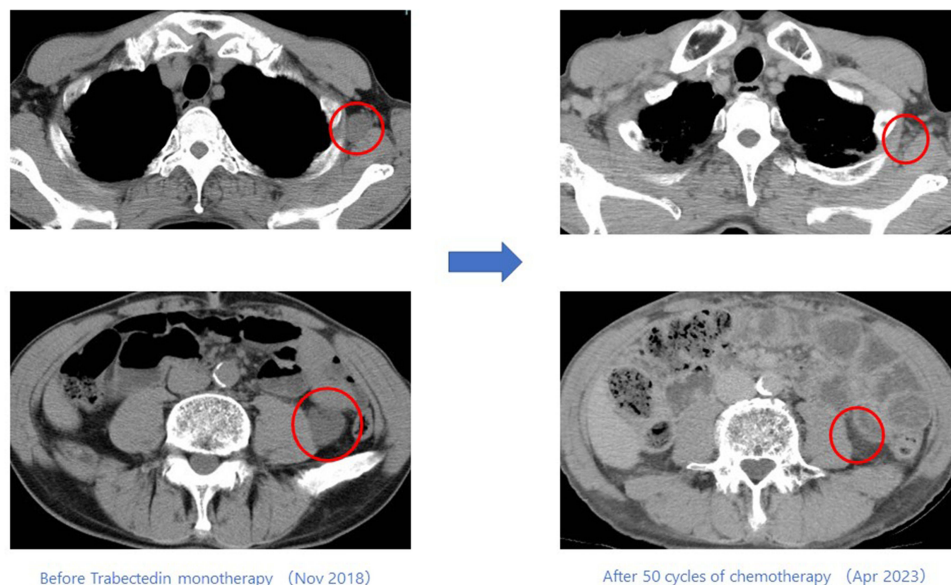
Changes in imaging of Case 2 patient before and after trabectedin administration (Chest and abdominal CT) Metastatic site of left axillary lymph node and retroperitoneal metastasis showed a complete remission after 50 cycles of trabectedin monotherapy compared to the findings of pre-treatment.
